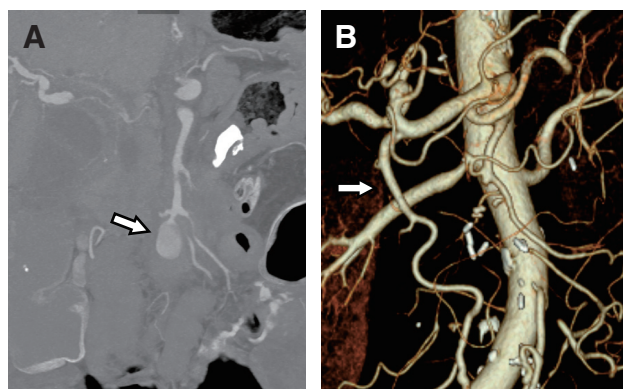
Case 2: pre- and post-operative CT. (A) CT showing the SMA aneurysm (arrow) and narrowed SMA distal to the aneurysm. (B) 3-dimensional CT after the resection of the infective SMA aneurysm and vascular reconstruction. The gastroepiploic artery was anastomosed to the distal part of the SMA (arrow). CT: computed tomography; SMA: superior mesenteric artery
